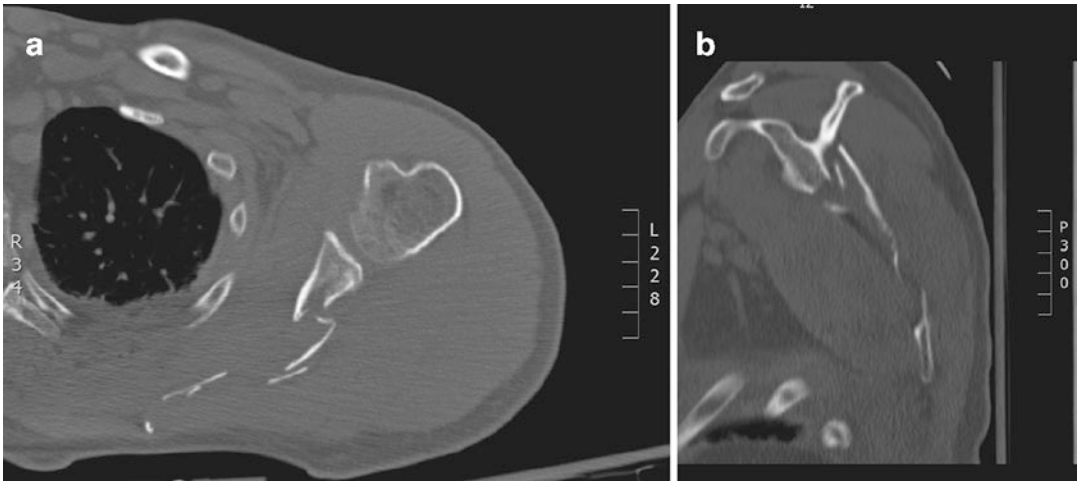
(a, b) Axial (a) and coronal (b) CT scan of the scapula fracture clarify the pattern of injury
